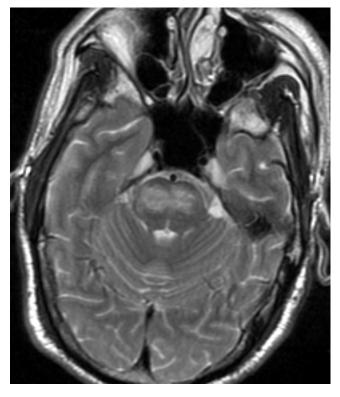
Axial T2 weighted MR image shows inhomogeneous high signal intensity abnormalities throughout the pons.
